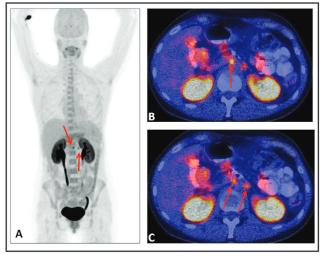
11 C-5-hydroxy-l-tryptophan positron emission tomography (PET)-computed tomography (CT) scanning 6 months after surgery, showing recurrent disease with retroperitoneal lymph node metastases (red arrows). (*A*) Coronal image, (*B*, *C*) transaxial fused PET-CT images.
